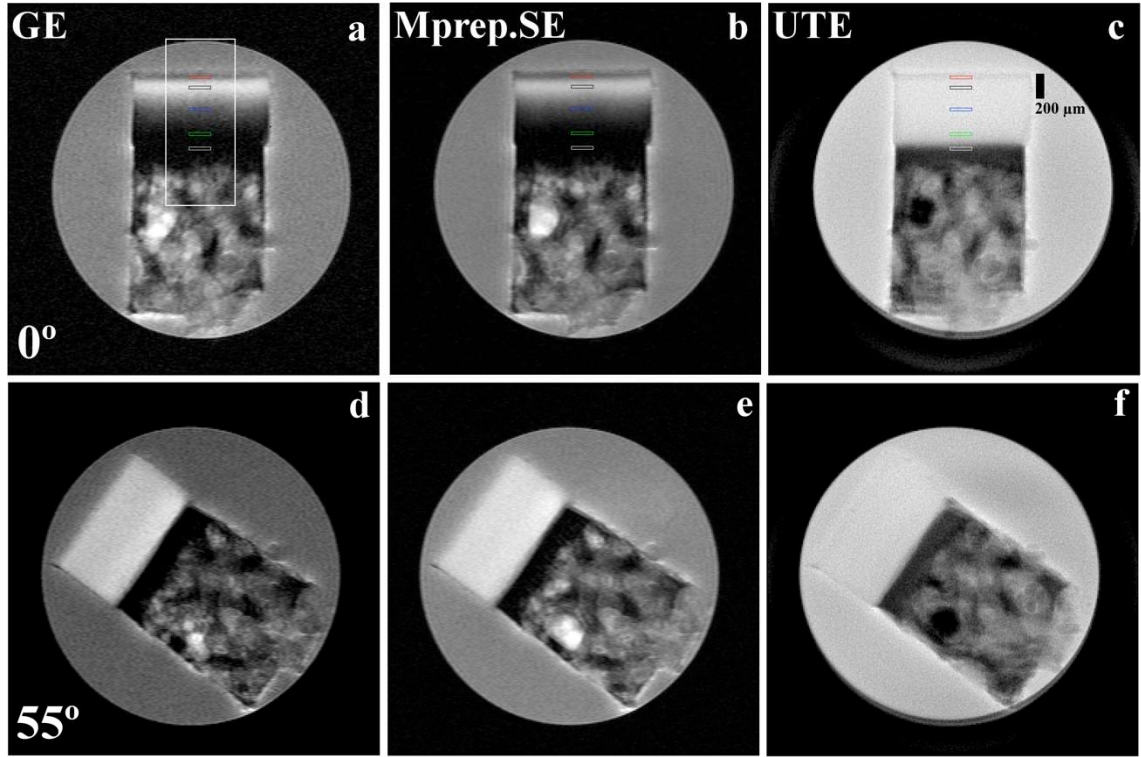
T2-weighted intensity maps using a Gradient Echo (GE), magnetized prepared Spin Echo (Mprep.SE), and Ultra-short Echo (UTE) sequence of cartilage bone plugs at 0° (a, b, and c) and 55° (d, e, and f) respectively (the direction of the B₀ is vertically up in the figure). The white ROI box represents the region of interest for analysis. The smaller ROIs within represent the zonal locations where red, black, blue, green, and white ROIs represent SZ, TZ, RZ1, RZ2, and ZCC respectively. All images are displayed using the same max and min intensity limits.
